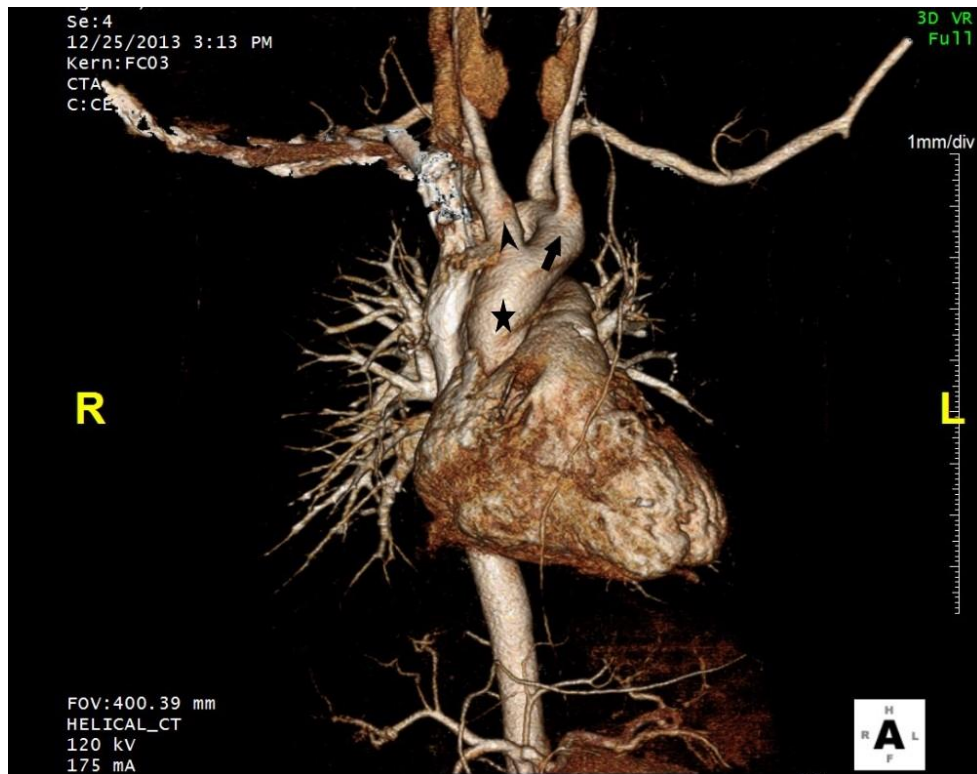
The 3D computed tomography angiography image shows the continuity of the ascending aorta (black mark) as the left-anterior (black arrow) and right-posterior (black arrowhead) arcus. While the right arch gives the right common carotid and right subclavian artery branches separately, the left arch gives the left common carotid artery and left subclavian artery branches.
